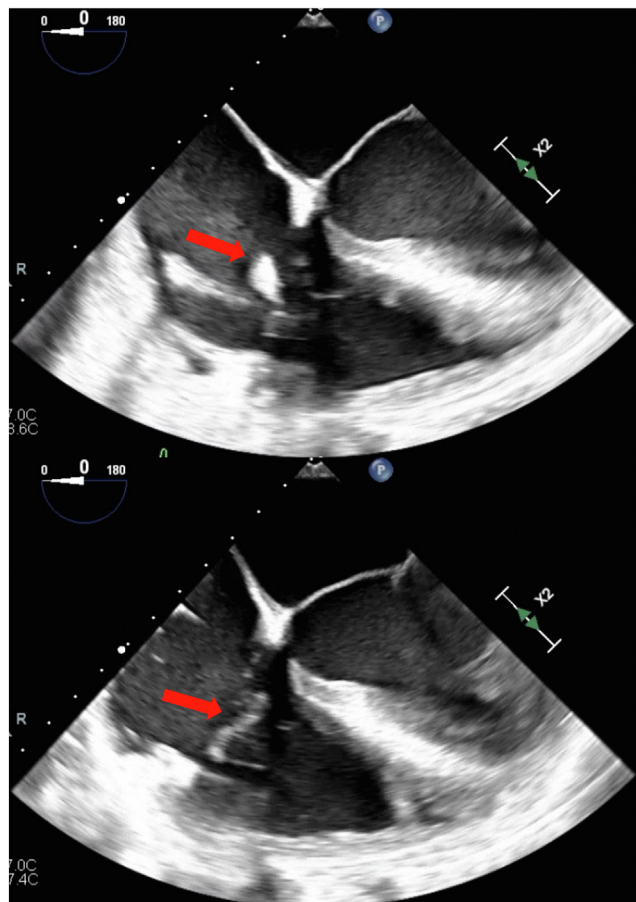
Pre and post procedural transesophageal echocardiography imaging.
